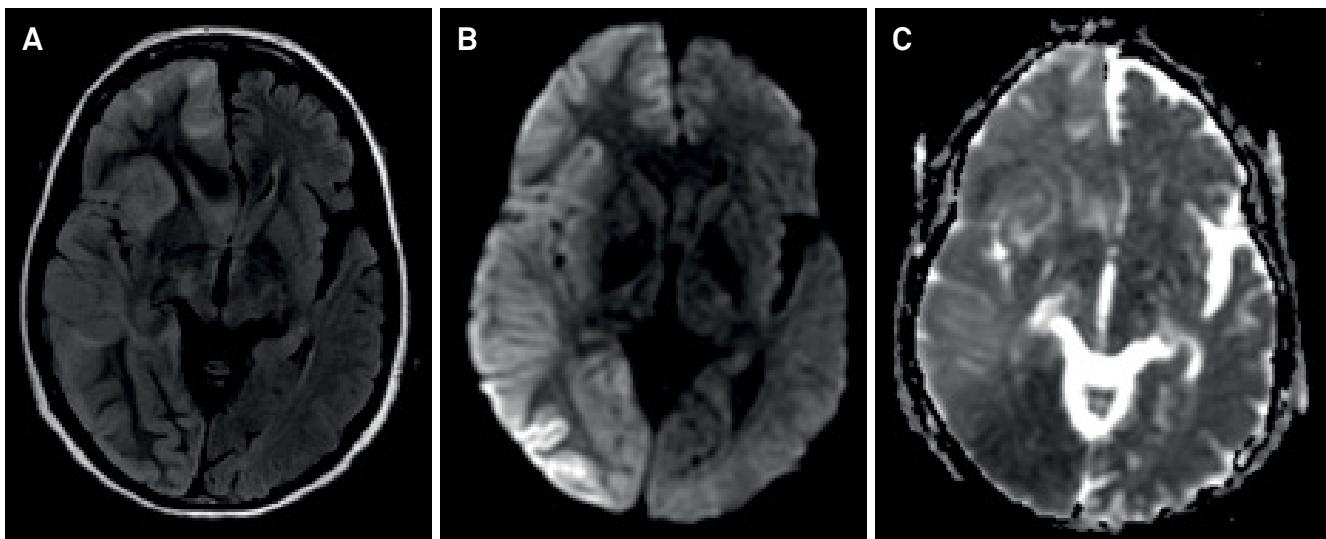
Brain MRI during *epilepsia partialis continua*. FLAIR (A) image: right hemispheric increased signal intensity and swelling at the cortical gray matter and subcortical white matter and mild midline shift. DWI (B) and ADC map (C): cortical hyperintensity and restricted diffusion. DWI: Diffusion weighted imaging; ADC: Apparent diffusion coefficient
